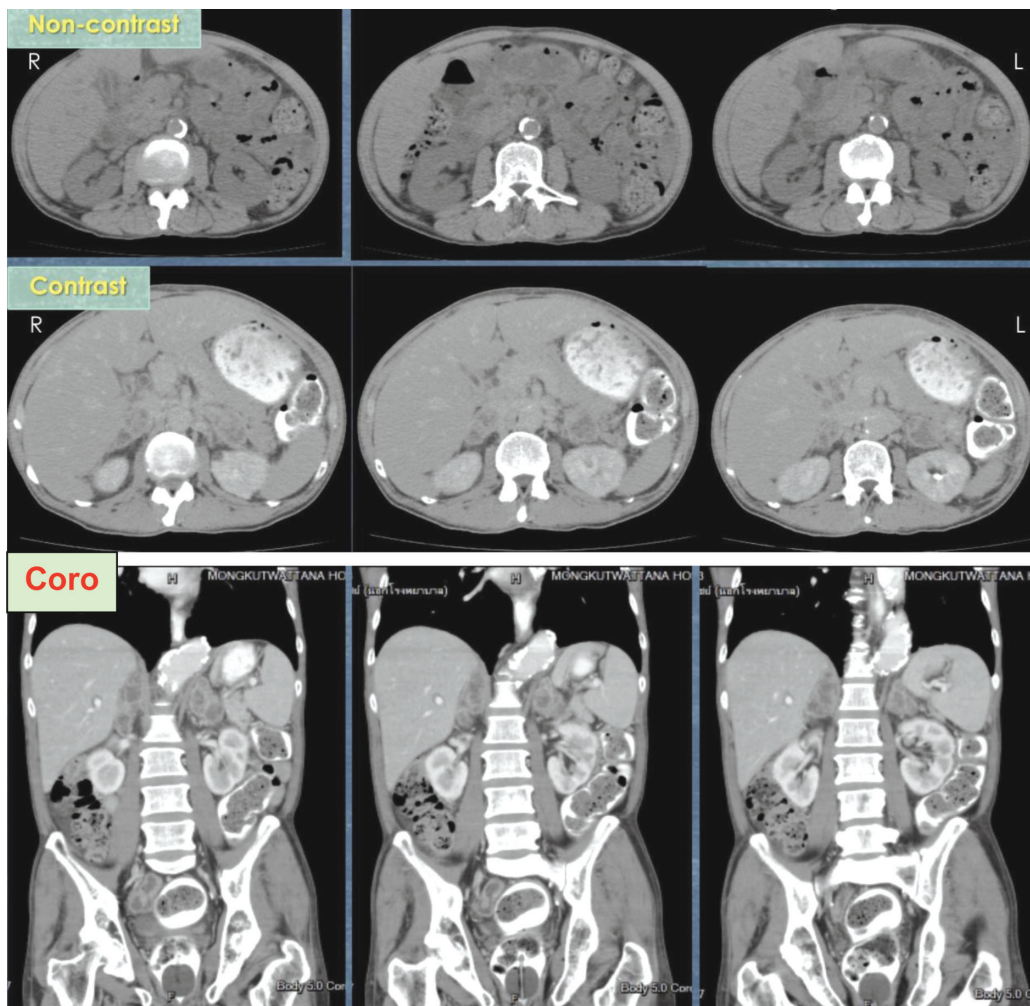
CT scan of the abdomen and pelvis with oral and intravenous contrast. Upper row: the unenhanced image; the middle and lower rows: contrast-enhanced CT scans show enlargement of bilateral adrenal glands with peripheral rim enhancement on the axial (middle) and coronal (lower) views
